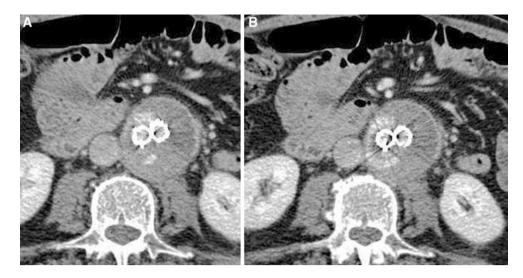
Type 2 endoleak at contrast-enhanced CT
